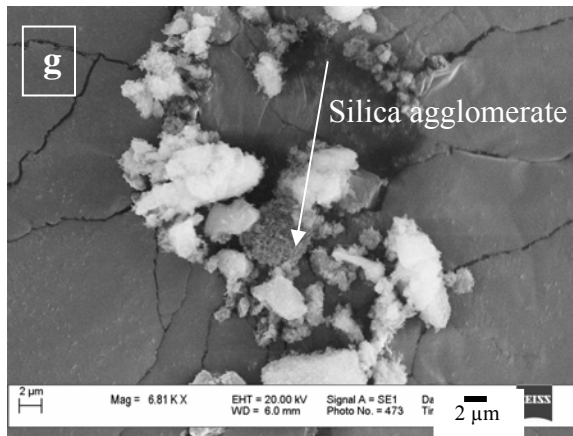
Effect of ultrasonic energy on deagglomeration and coating of silica particles on microfine lactose at 35% ultrasound amplitude, 5°C, 1/10 (w/w), and 78 bar (a) typical silica (R972) agglomerate, (b) presence of R972 silica agglomerates at ultrasound energy of 3.5 MJ/m³, (c) deagglomeration and coating of R972 silica agglomerates at ultrasound energy of 3.5 MJ/m³, (d) presence of R972 silica agglomerates in the size of 400-600 nm on the surface of microfine lactose, (e) presence of very thin coating of R772 silica on the surface of microfine lactose at ultrasound energy of 7.5 MJ/m³, (f) higher magnification of thin coating of R972 silica on the surface of microfine lactose, and (g) presence of M5 silica agglomerates even at 7.5 MJ/m³ ultrasound energy.
